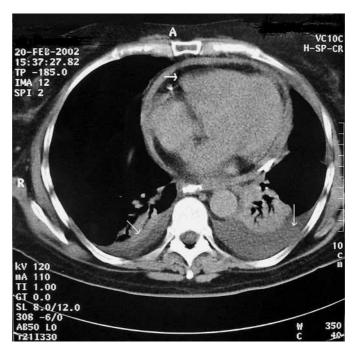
Computed tomogram of the chest, showing pericardial effusion (thick arrow) and bilateral pleural effusions (thin arrows), with basal atelectasis on the left side.
